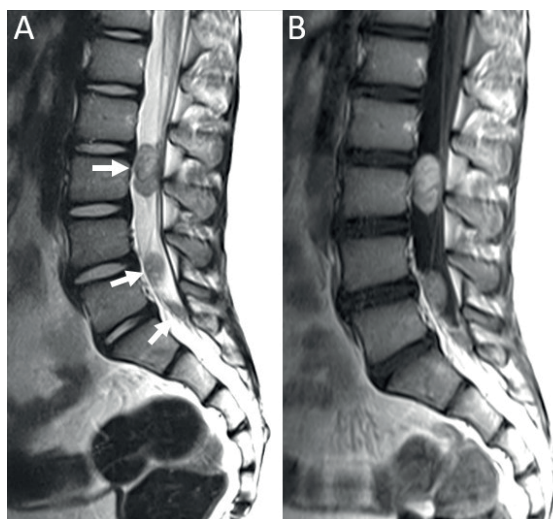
Lumbar spinal MRI shows multiple intradural masses, which are T2 isointense to the spinal cord (arrows, sagittal T2-weighted image, A) and enhancing homogenously following gadolinium based contrast material administration (sagittal T1-weighted postcontrast image).
